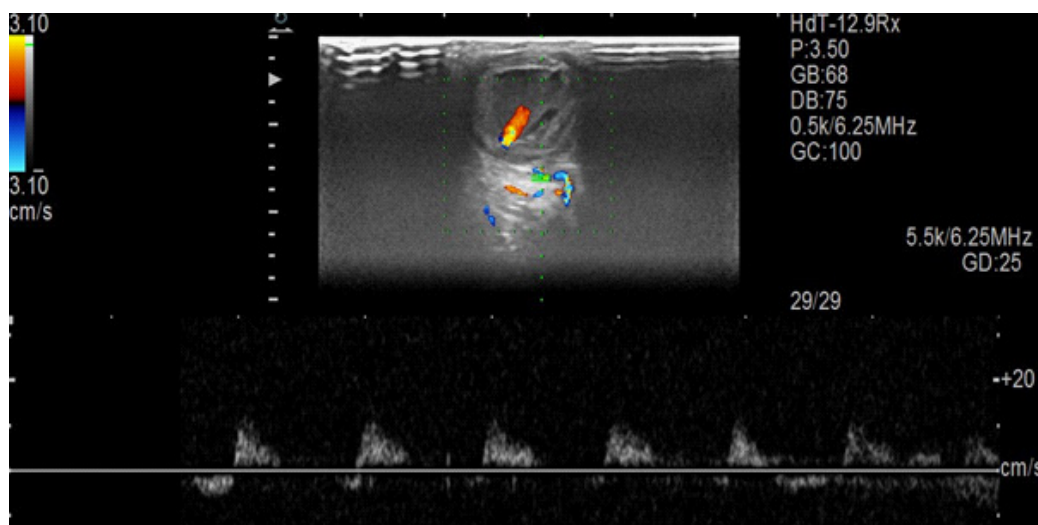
Spectral doppler waveform of the occipital artery.
